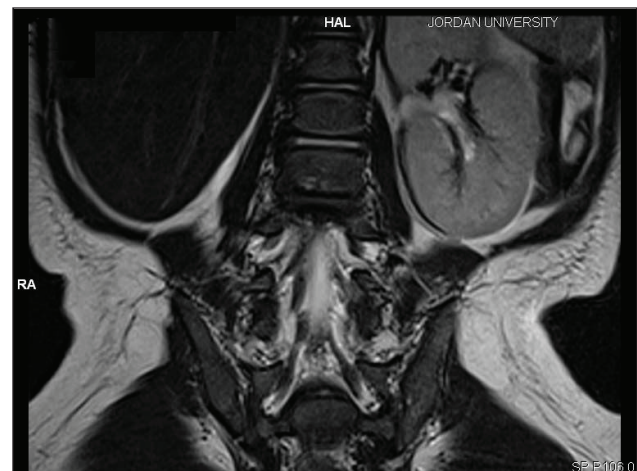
Coronal T2-weighted image of the abdomen. Note the solitary hypertrophied left kidney.
